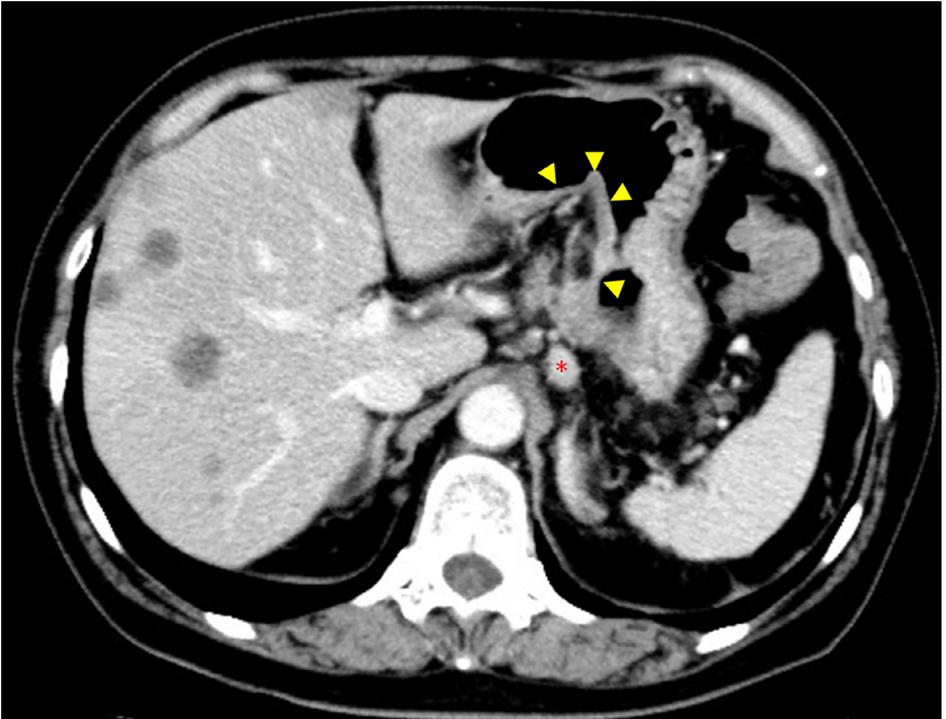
Contrast-enhanced CT axial view at the first visit. Contrast-enhanced CT showed tumor of pancreatic body. The serosal layer of the stomach attached to the pancreas tumor was destructed and tumor invaded into the stomach cavity wall (yellow arrow). Lymph nodes in the left gastric artery lymph node were enlarged (red asterisk). However, most of the serosal layer of the stomach kept in shape.
